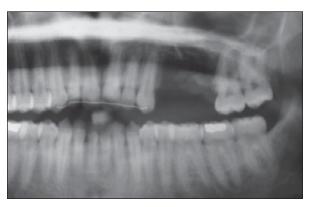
Panoramic radiograph depicting the significant alveolar bone defect on the maxillary left side.
